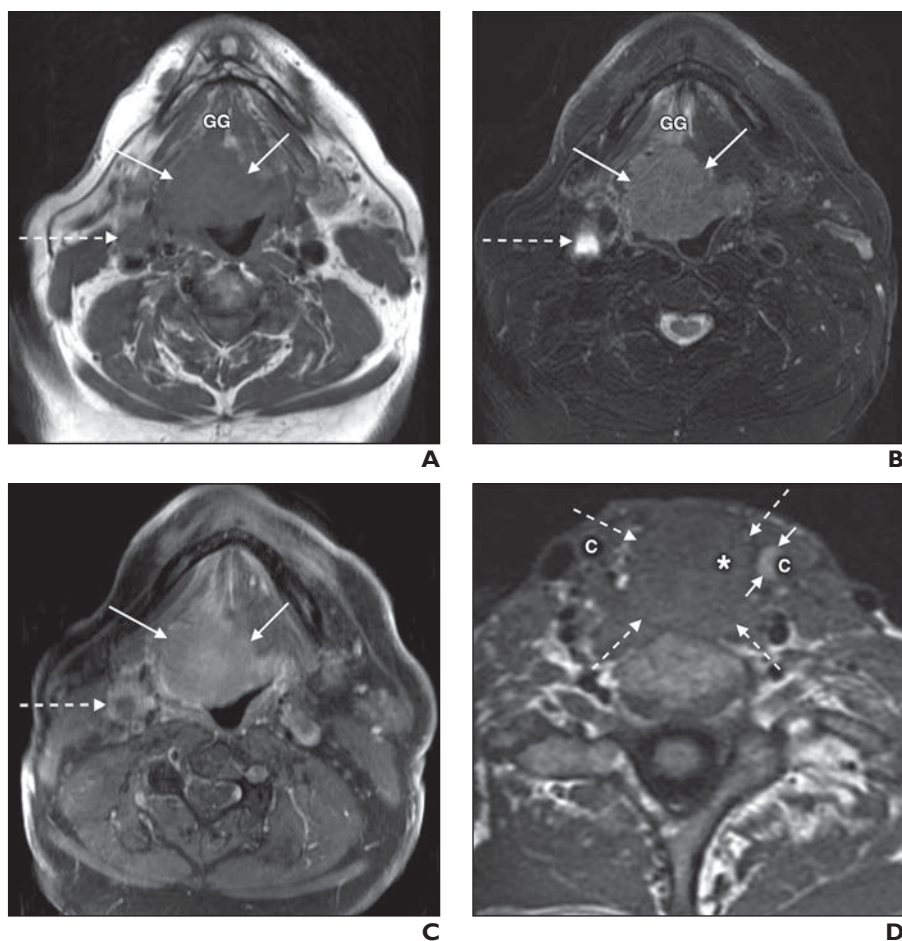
Standard head and neck MRI sequences. A–C, 69-year-old man with odynophagia and hemoptysis. Axial T1-weighted image (5-mm thickness) (A) shows large oropharyngeal soft-tissue mass (solid arrows) infiltrating fat planes and muscle at base of tongue and floor of mouth. Mass was diagnosed as *p16*-negative squamous cell carcinoma of base of tongue and was categorized as T4a given infiltration of genioglossus (GG) muscle. Enlarged metastatic right level 2A lymph node is also present (dashed arrow). Axial T2-weighted image with fat suppression (B) shows intermediate signal intensity of mass (solid arrows), differentiating it from hypointense muscle and suppressed fat. Image also shows peritumoral edema of anterior floor of mouth and GG muscle as well as marked hyperintensity of metastatic right level 2A lymph node (dashed arrow), consistent with central necrosis. Axial contrast-enhanced T1-weighted image with fat suppression (C) shows moderate diffuse enhancement of mass (solid arrows). Right level 2A lymph node (dashed arrow) shows irregular peripheral enhancement, consistent with central necrosis. D, 66-year-old man with recurrent squamous cell carcinoma after laryngectomy. Axial T1-weighted image (two-slice thickness), reconstructed from sagittal 3D acquisition (CUBE, GE Healthcare), shows large soft-tissue mass involving neopharynx and surgical bed (dashed arrows), traversed by nasogastric tube (asterisk). Patient had experienced recent left cerebral hemisphere ischemic infarction. Sequence has black-blood characteristics, and both common carotid (denoted by C) lumens are well visualized. Left common carotid artery shows intramural hematoma (solid arrows), consistent with hemorrhage into atherosclerotic plaque.
